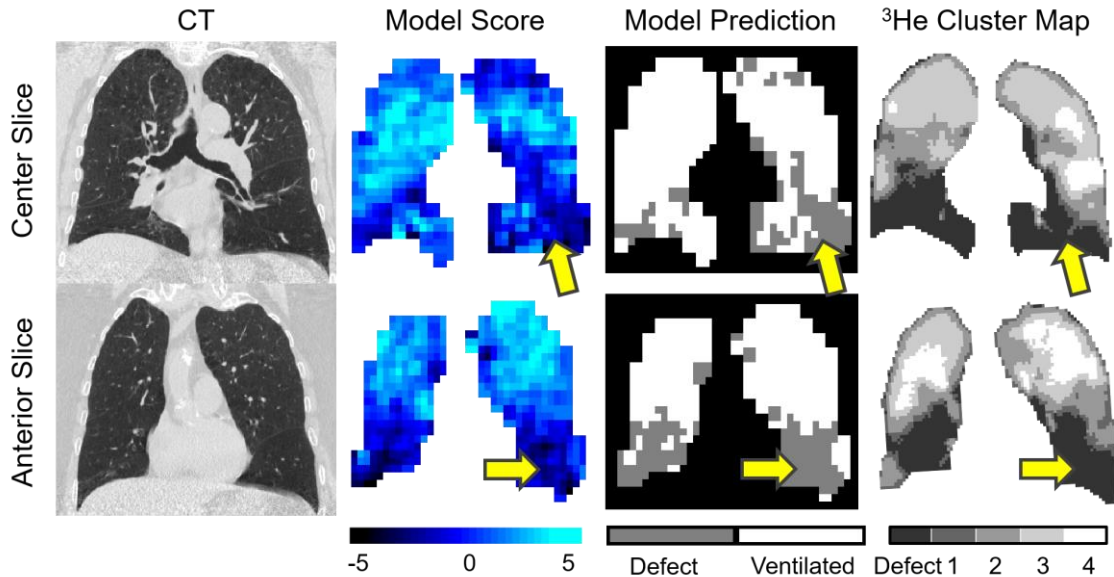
CT, Model predicted score, model binary prediction and ^3He cluster map for a test subject showing representative centre and anterior slices.
